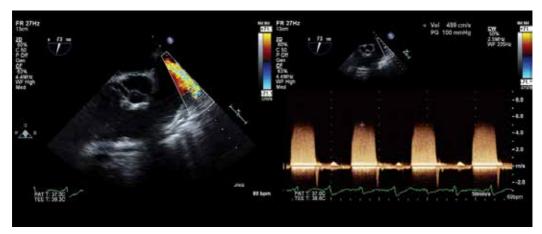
Colour Doppler (left) and continuous wave Doppler (right) imaging of an RVAD outflow anastomosis onto the main pulmonary artery
